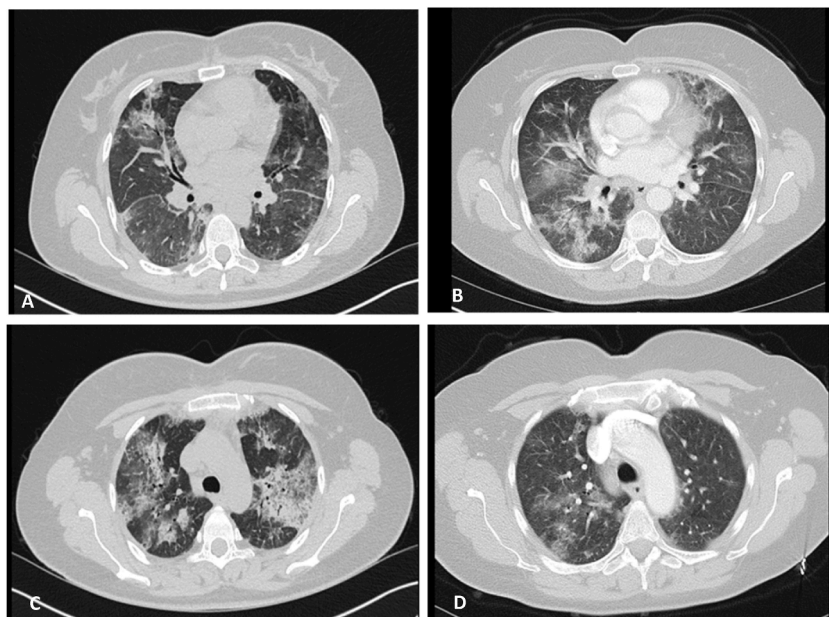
Chest CT taken four months apart (A + C on the left column on August 21 and B + D on the left column on January 22).
